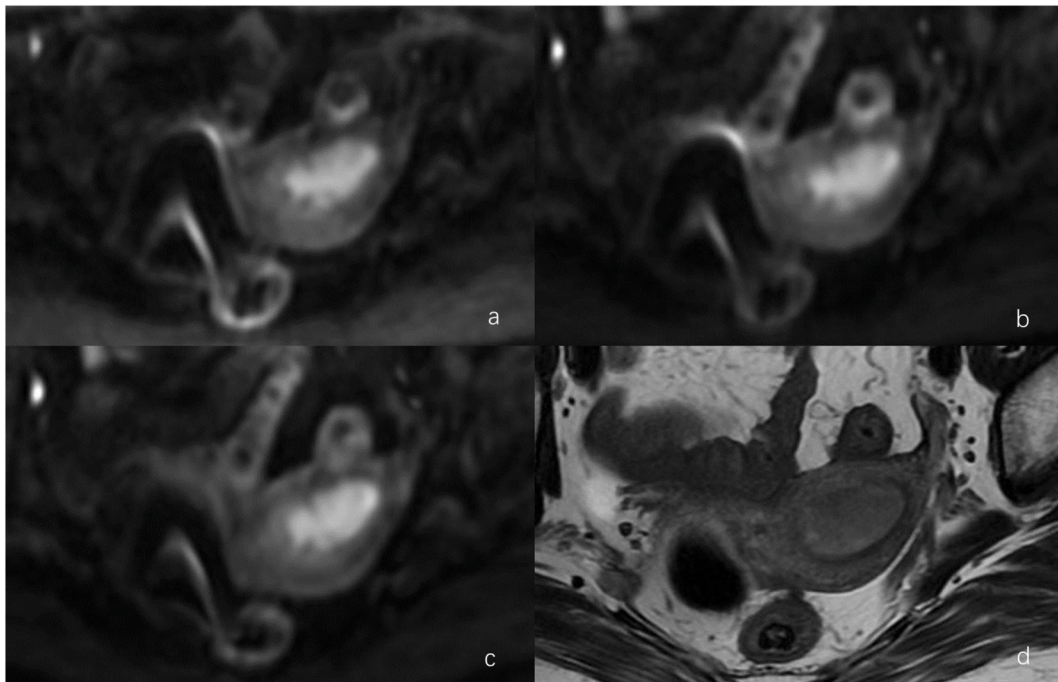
DWI and T2WI maps of patients with endometrial cancer. a) ssEPI DWI, b) MUSE DWI, c) RPG-MUSE DWI, d) T2WI. Among the three DWI sequences, the RPG-MUSE DWI image had fewer artifacts and less anatomical distortion.
